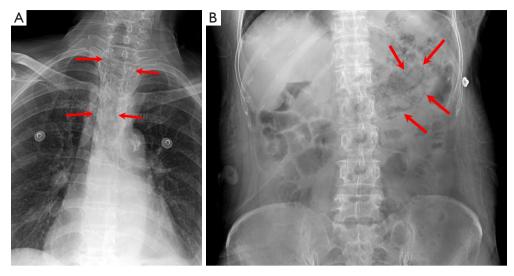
Plain radiographs of a patient with emphysematous esophagitis with gastritis taken in the emergency room. There are liner or dot-like air density gathered in the upper mediastinum (arrows) on a chest radiograph (A). There are air shadows along the border of the stomach (arrows) on an abdominal radiograph (B).
